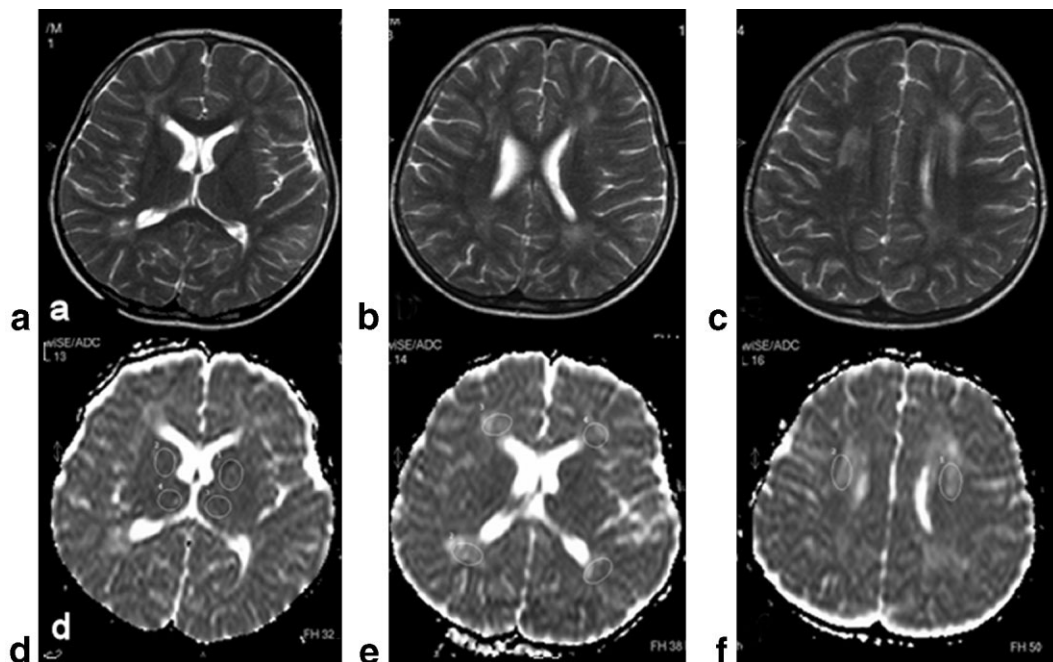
Findings in a 3-year-old girl with stage II SSPE. a–c: Axial T2-weighted image (TR = 4530 msec, TE = 100 msec) shows asymmetric high signal intensity lesions in the periventricular white matter. d: ADC maps show high ADC values in the basal ganglia (873 and $897 \times 10^{-6}\text{mm}^2/\text{sec}$) and thalamus (846 and $821 \times 10^{-6}\text{mm}^2/\text{sec}$). e and f: ADC maps reveal high signal intensity and ADC values in the periventricular (1124 , 1166 , 1197 , and $1098 \times 10^{-6}\text{mm}^2/\text{sec}$) and deep white matter (1427 and $1429 \times 10^{-6}\text{mm}^2/\text{sec}$).
